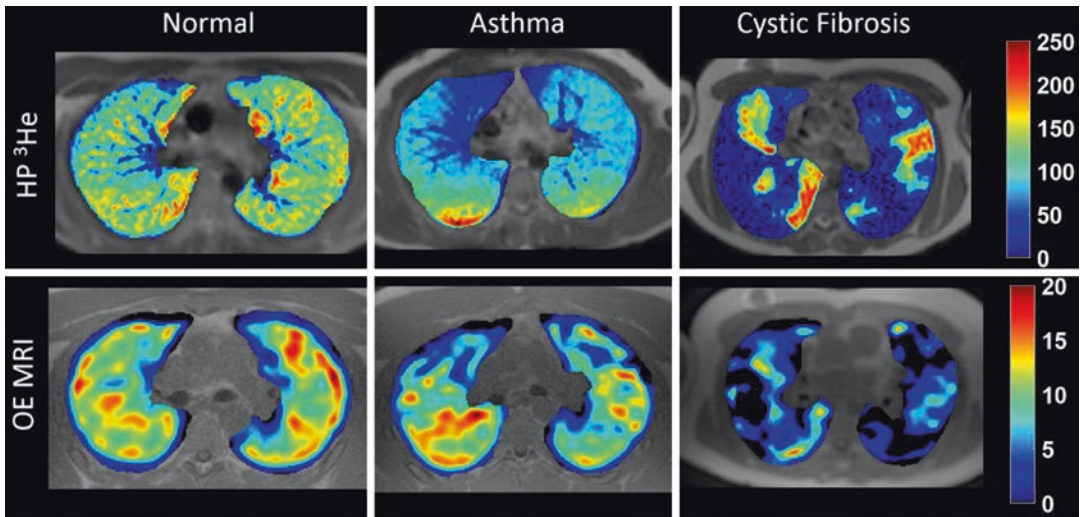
Comparison of hyperpolarized (HP) ^3He MR images (top) with OE MRI (bottom) acquired in the same healthy normal (left) asthma (middle) and cystic fibrosis (right) subjects. In-plane spatial resolution for HP ^3He MRI is
